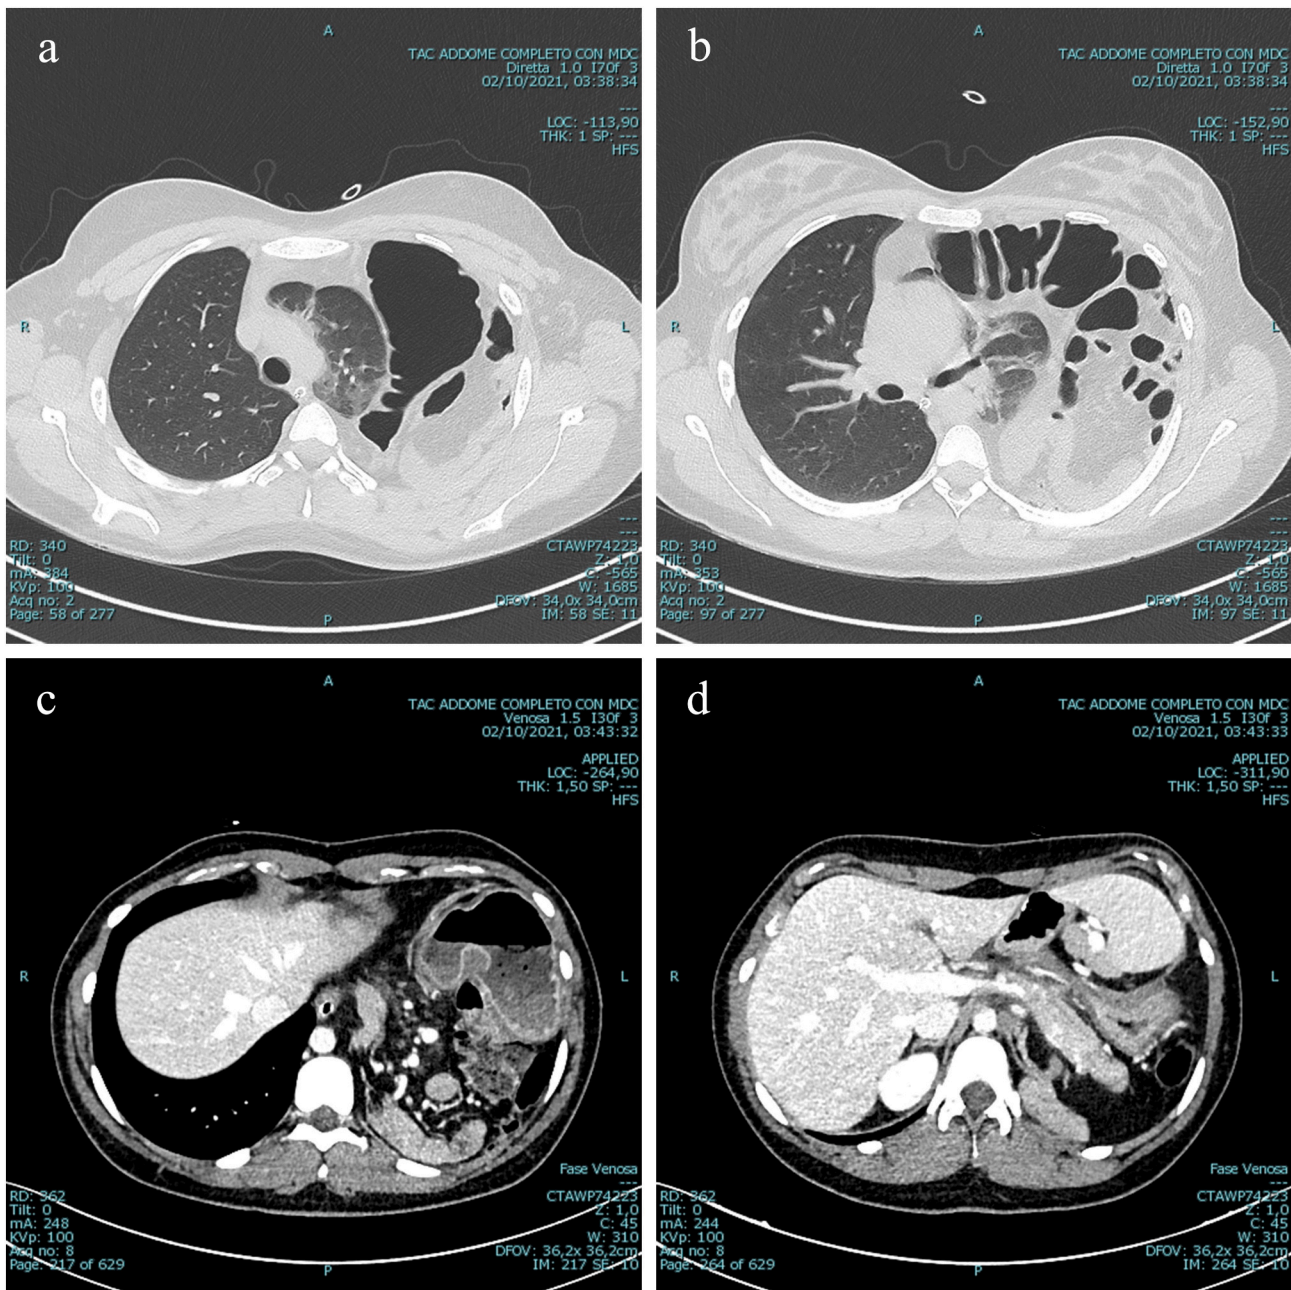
Axial images of Chest and Abdomen CT-scan showing the severe left lung hypoplasia (a), the size of the left diaphragmatic Larrey-type hernia (b-c) and the dislocation of the spleen (d).
